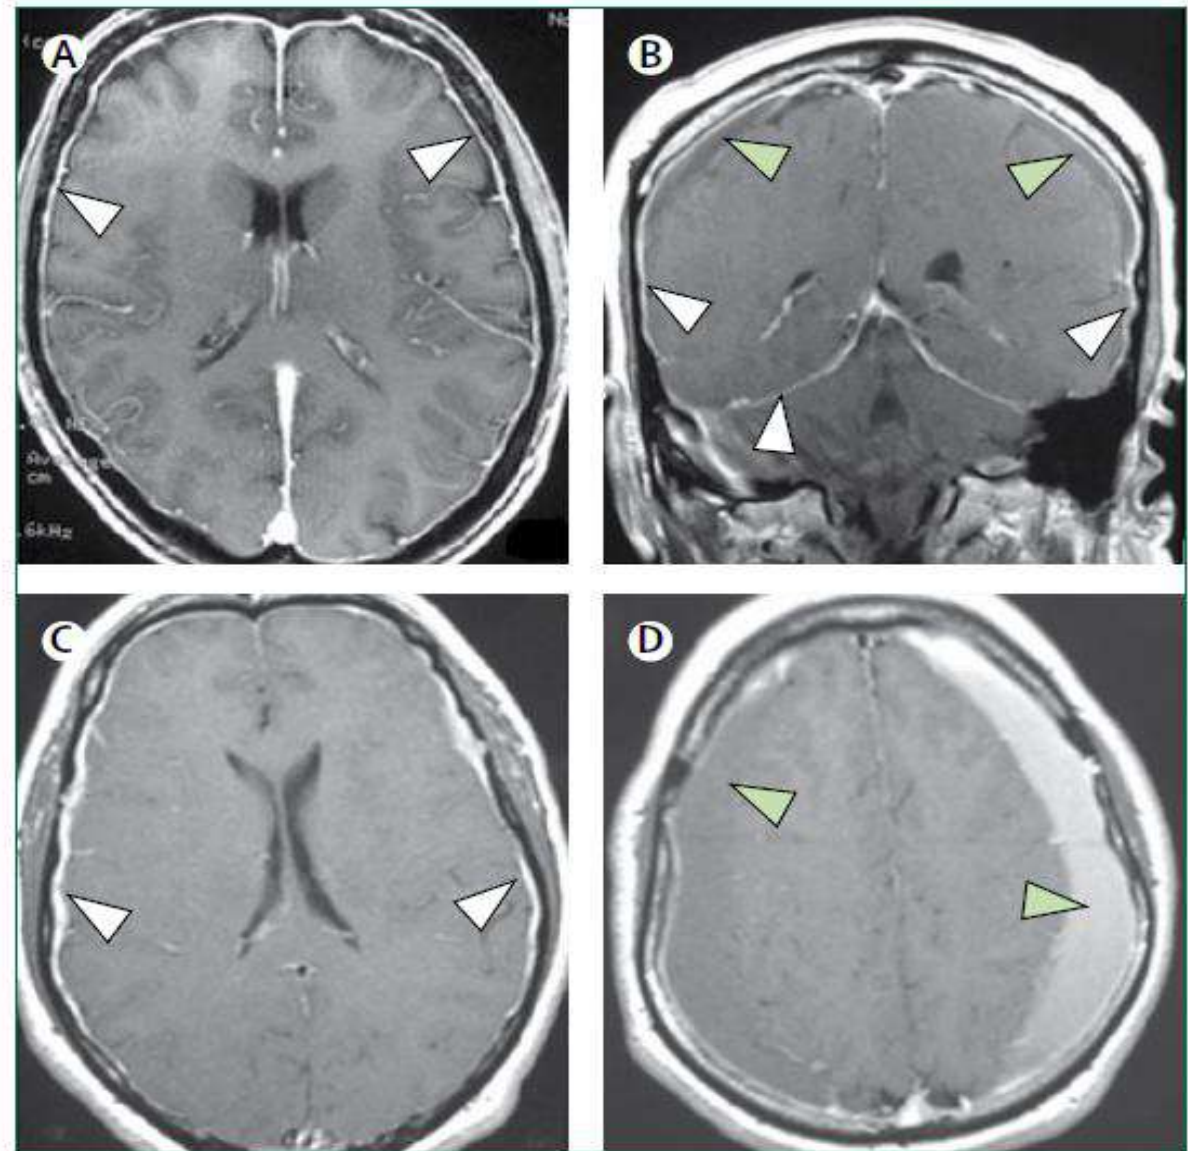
Brain MRI in patients with spontaneous intracranial hypotension
